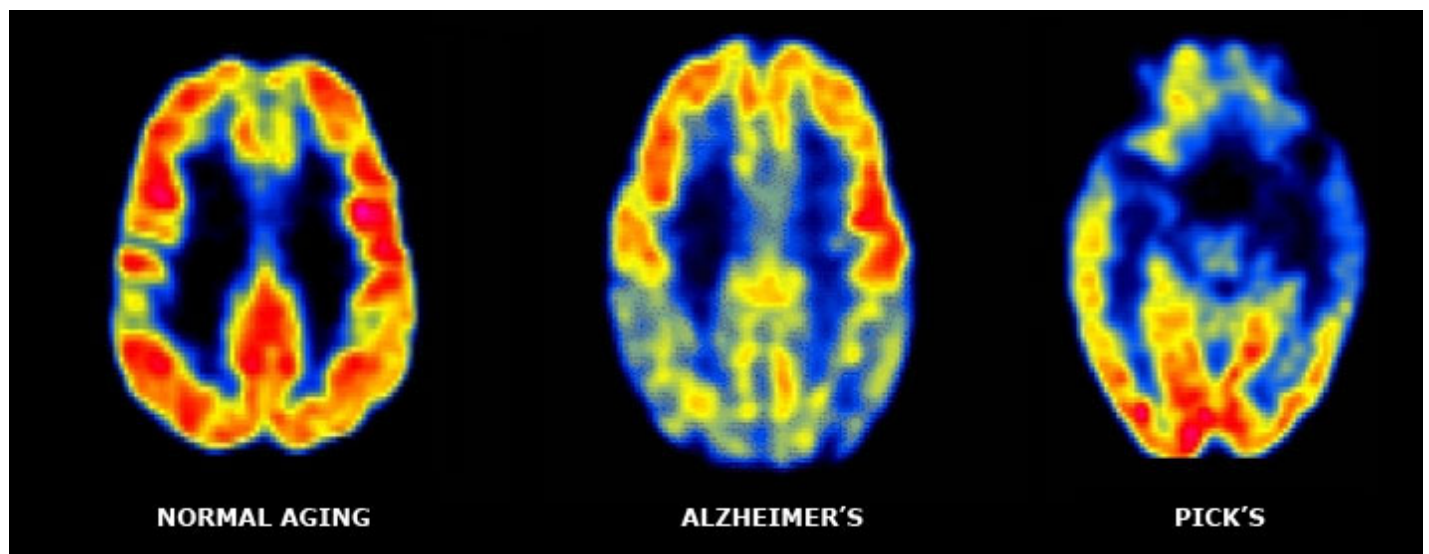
FDG PET images showing patterns of metabolic activity that are characteristic of patients with Alzheimer’s disease, Pick’s disease (fronto-temporal dementia) and elderly individuals with no dementia. Red, high FDG uptake, Blue, low FDG uptake.
